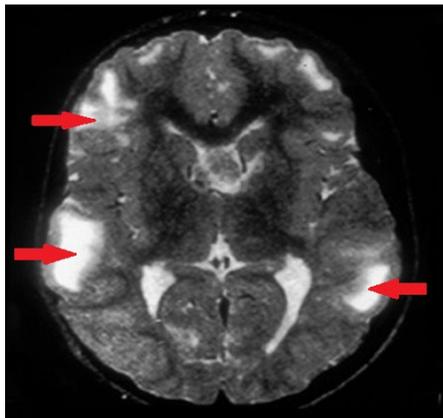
Brain Non contrast T2-weighted magnetic resonance image for 6 y old boy, demonstrates extensive high-signal cortical lesions.
